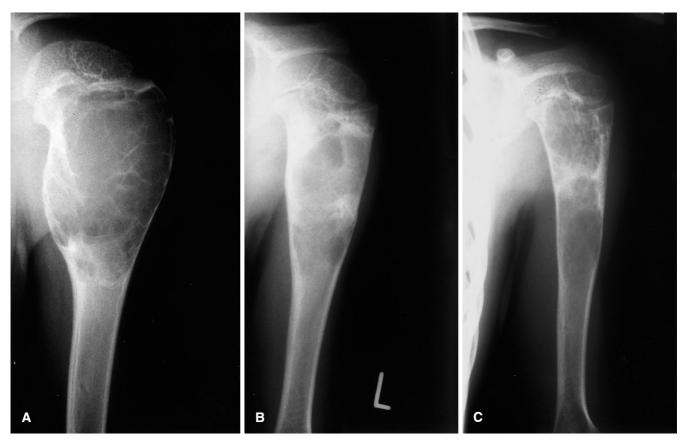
Preoperative radiograph showing an aneurysmal bone cyst of the proximal humerus. B Radiograph 4 months post-operatively showing remineralisation and the beginning of reconstitution of the bone. C Radiograph 18 months post-operatively showing further resolution of the lesion with some residual lucency
